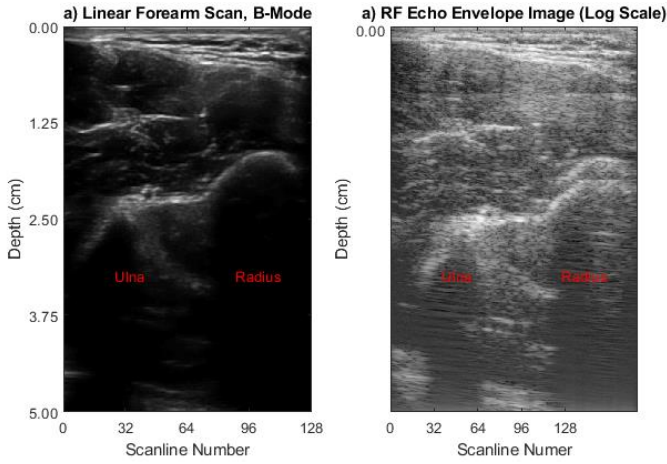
A comparison of a scan of the forearm from a linear transducer (L14-5/38, Ultrasonix, Canada) with the a) brightness-mode and b) logarithmic echo envelope of the radiofrequency data. The brightness-mode data is visually enhanced to remove the speckle for a smoother image, but the speckle in the radiofrequency data can be leveraged to understand the scattering interactions of the acoustic wave in certain materials.
